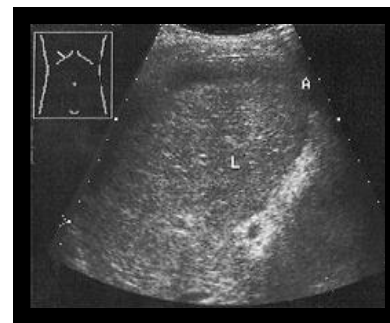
Ultrasound liver showed blunted liver edge, irregular surface and Coarse parenchymal texture. (Sever fibrosis)
